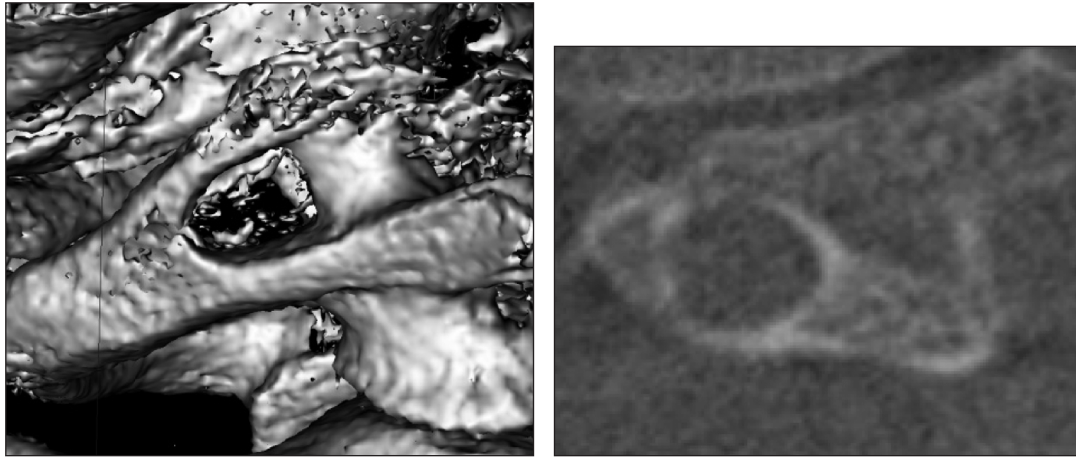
a) Ponticulus posticus on CBCT 3D reconstruction image. b) Ponticulus posticus on CBCT sagittal section image.
